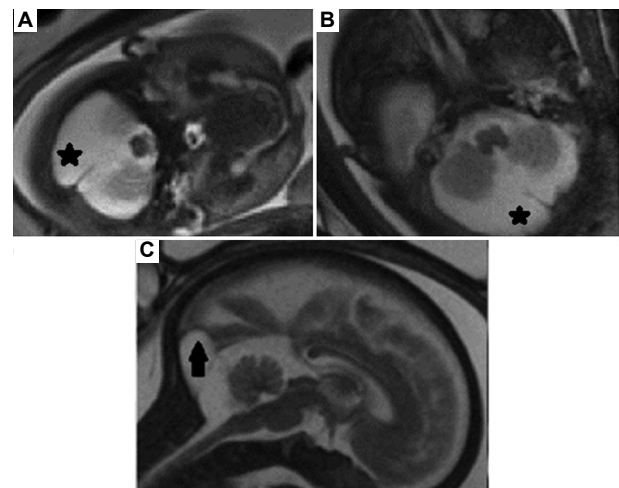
MRI findings of a posterior fossa arachnoid cyst. (A-C) MRI images of a 35-week fetus demonstrate extra-axial enlargement of the posterior fossa (black star), accompanied by indentation to the tentorium cerebelli (black arrow). The findings are consistent with an arachnoid cyst.
